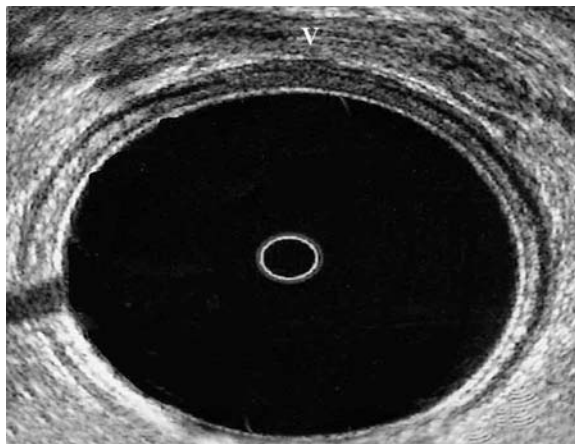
37. Sonographic view of the vagina (*V*)
